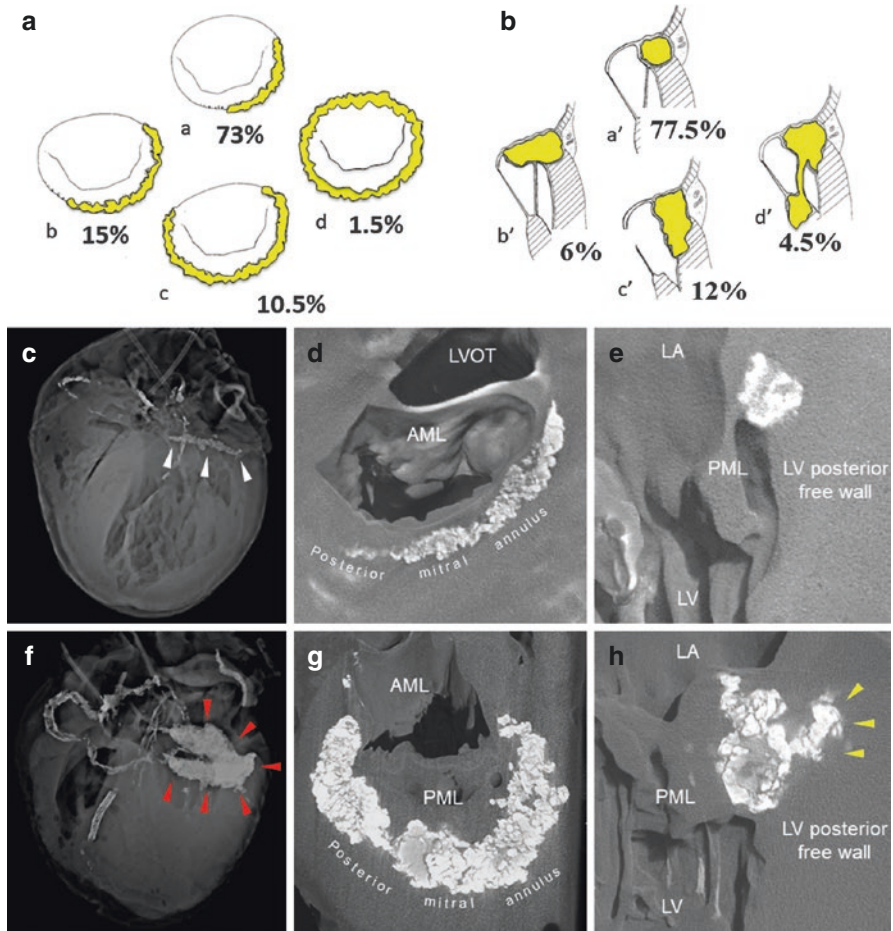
Mitral annular calcification. The classification of mitral annular calcification includes circumferentially (a) and vertically (b). Calcification involves at least one third of the whole posterior annulus in 88% of patients (73% have equal or less than 1/4 of the annulus; 15% have greater than 1/4), the whole posterior annulus in 10.5%, and circumferential in 1.5% (a). Vertical calcification is limited to the annulus only 77% and extends into the leaflet tissue in 6%, the myocardium in 12% of patients, and the papillary muscles in 4.5% (b). Reproduced with permission from Carpentier et al. [97]. (c–e) A heart from a 87-year-old white female with history of coronary artery disease, diabetes mellitus, and hyperlipidemia. MAC (white arrow heads) was detected by postmortem radiograph (c) and micro CT images (d, e). Transverse micro CT image showed MAC involving approximately two third of the whole posterior annulus (d). Calcification was limited in the annulus itself in vertical image (e). (f–h) A heart from a 42-year-old white male with history of end-stage renal disease on dialysis with severe mitral valve stenosis secondary to annular calcification. A postmortem radiograph (f) and CT images (g, h) of the heart shows marked mitral annular calcification (red arrowheads) that involves the whole posterior mitral annulus and the attachment of the anterior leaflet (g). Vertically, the calcification was involved the annulus itself and extends to the leaflet tissue and the ventricular myocardium (yellow arrowheads) (h). Abbreviation: AML, anterior mitral leaflet; CT, computed tomography; LA, left atrium; LV, left ventricle; LVOT, left ventricular outflow tract; MAC, mitral annular calcification; PML, posterior mitral leaflet
